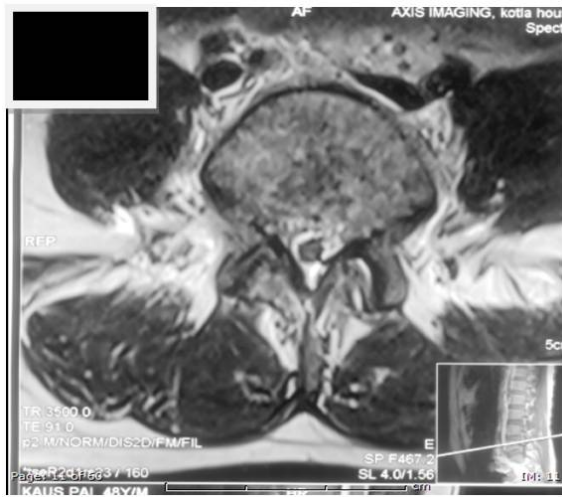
and 2b (a) MRT2W axial image showing heterogeneous marrow with small epidural soft tissue component and clumped nerve roots. (b) CT guided bone biopsy from L5 vertebral body.
